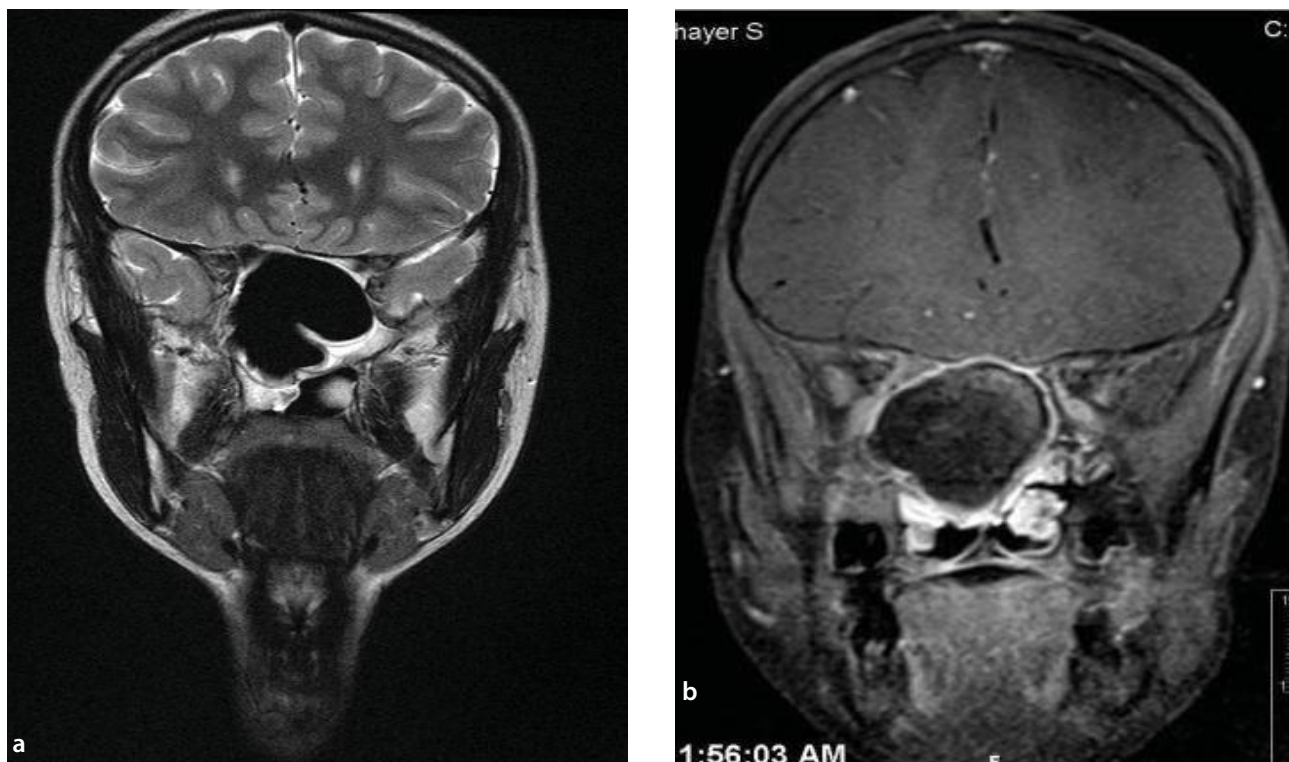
(a) Coronal T2 and (b) coronal FLAIR showing enhanced fat saturated at the level of the sphenoidal sinus showing non-enhancing, heterogeneous, predominantly hyperintense content and a peripheral rim of enhancement representing inflamed mucosa, typically seen in allergic fungal sinusitis. The brain parenchyma is normal. No evidence of intra axial extension.
